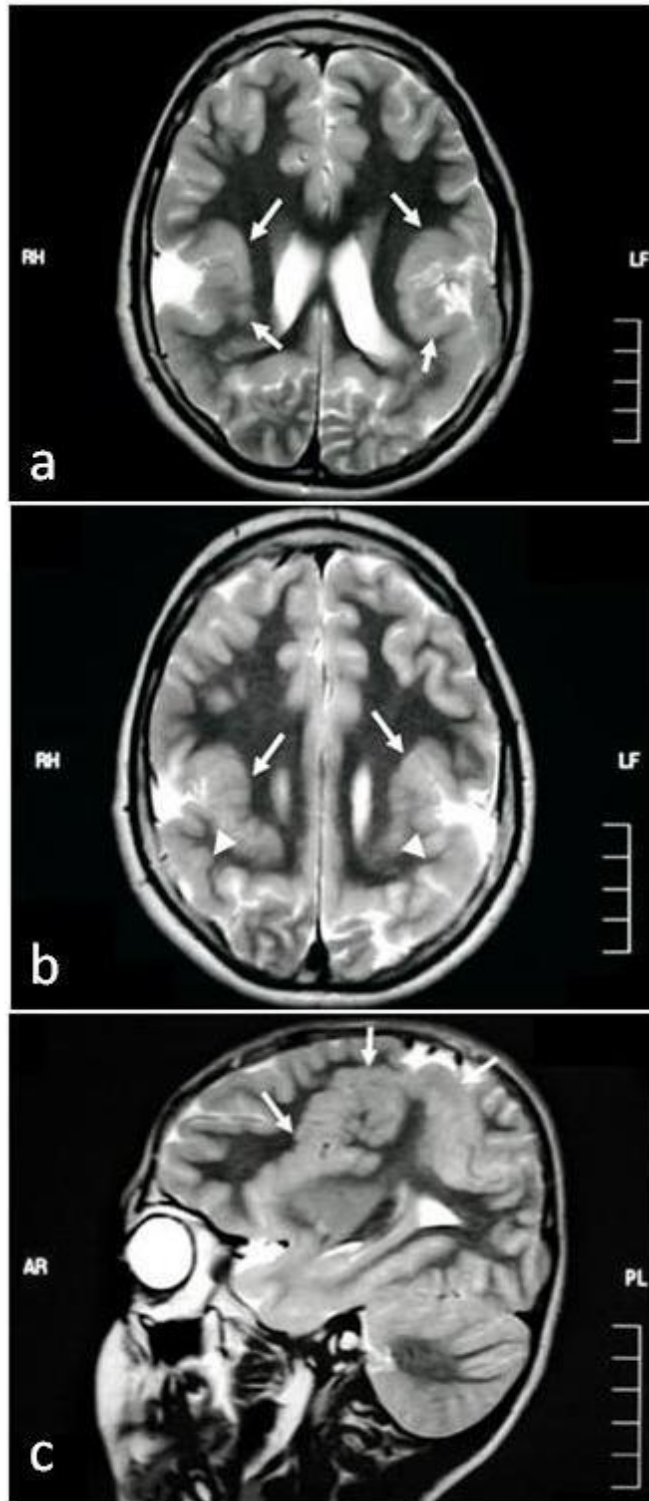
A 11-year-old boy. (a, b) Axial T2-weighted MR scans demonstrate that the sylvian fissures are abnormally formed bilaterally (white arrows) and are lined by polymicrogyric cortex extending posteriorly into the parietal parasagittal area (arrowheads), (c) Sagittal T2-weighted image shows polymicrogyria of the perisylvian cortex, posteriorly extending into the parieto-occipital cortex (white arrows).
